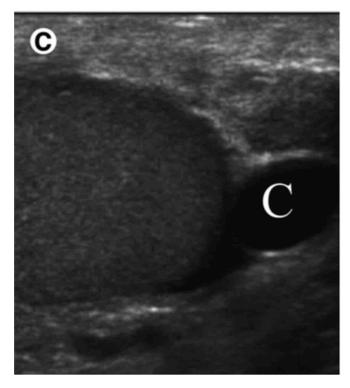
Epididymal cysts. (a) Small epididymal cyst (arrow). (b) Large epididymal cyst (labeled C) with a septum (arrow). (c) Epididymal tail cyst (labeled C). Adapted from Figure 20 of Pearl MS, Hill MC. Ultrasound of the scrotum. Semin Ultrasound CT MR. 2007;28(4):225–248. doi:10.1053/j.sult.2007.05.001.
